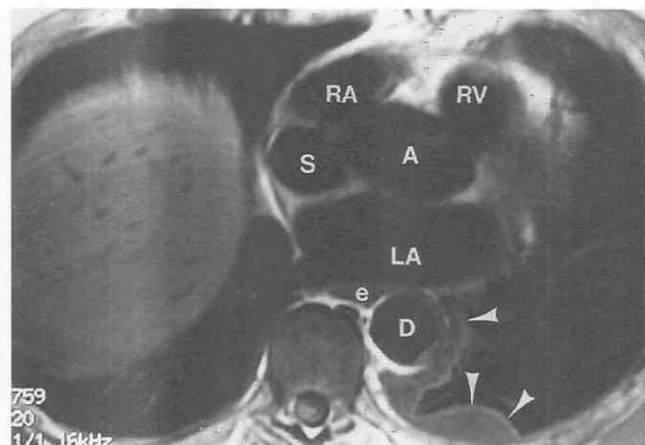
Axial MR image at the left atrial level in a patient with mesothelioma of the left hemithorax. Loculated pleural fluid (arrowheads) can be seen in the left posterior hemithorax. A, ascending aorta; D, descending aorta; e, esophagus; LA, left atrium; RA, right atrium; RV, right ventricle; S, superior vena cava.
